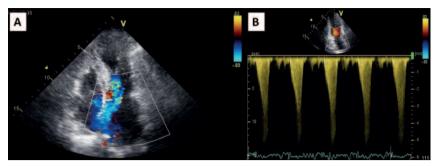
A) Color Doppler echocardiogram: accelerated flow in the left ventricle outflow tract (LVOT) and mitral regurgitation. B) Doppler spectrum characteristic of dynamic LVOT obstruction.
